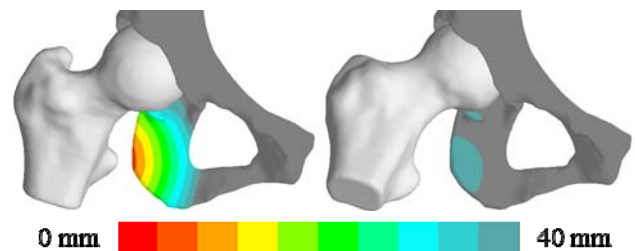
Measurement of IFS in a representative female subject from CT reconstructions. Dual-fluoroscopy determined positions of minimum (left) and maximum (right) IFS during level walking are shown.
